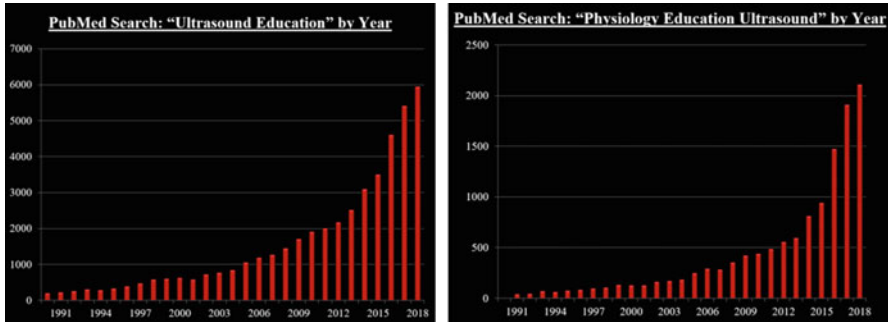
Left panel: Pubmed search by year for Ultrasound Education. Right panel: Pubmed search by year for Physiology Education Ultrasound
